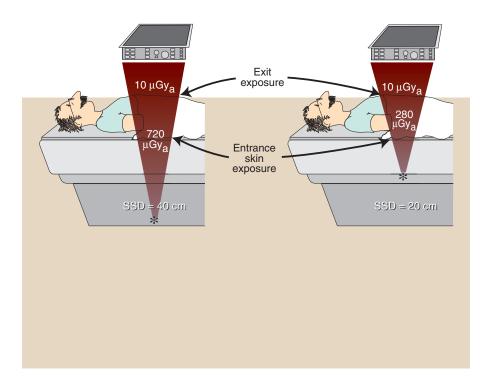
Patient entrance skin exposure (ESE) is considerably higher when the fluoroscopic x-ray tube is too close to the tabletop.
